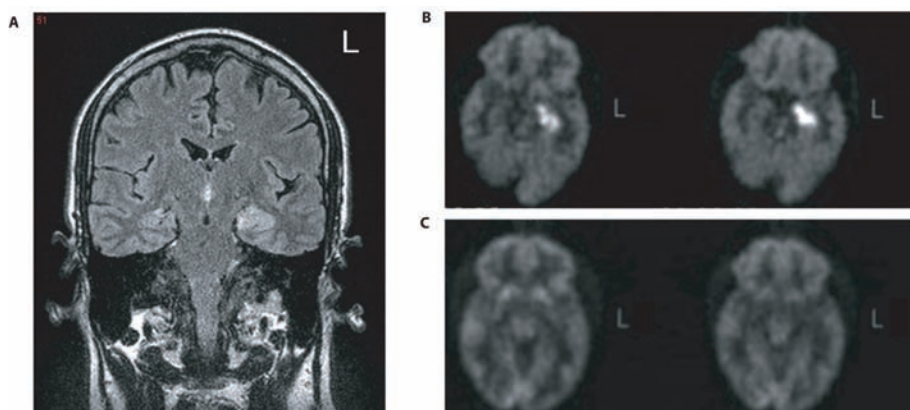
Radiological localisation of the seizure focus in TEA: (a) MRI scan showing high signal on T2-weighted imaging in the left medial temporal lobe of a patient with a flurry of attacks of TEA. (b) PET scan showing hypermetabolism in the left hippocampus at the time of the attacks, (c) with resolution after successful treatment 1 month later. (Reproduced from⁶).
